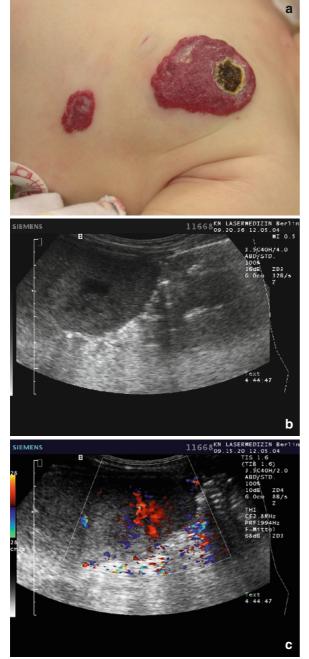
(a) Spontaneous ulceration caused by superficial hemodynamic steal effect. (b) Multiple infantile hemangiomas are associated with liver hemangioma. (c) Color-coded duplex sonography can detect the hypervascularization in the mostly hyposonic lesions
